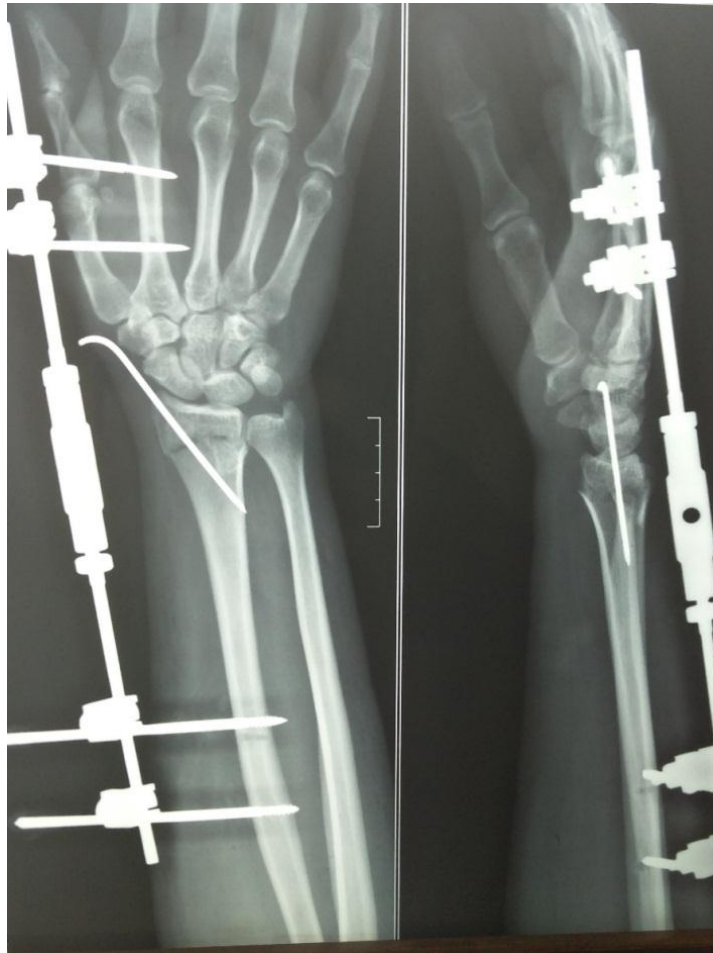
POST OPERATIVE XRAY AT ONE MONTH
